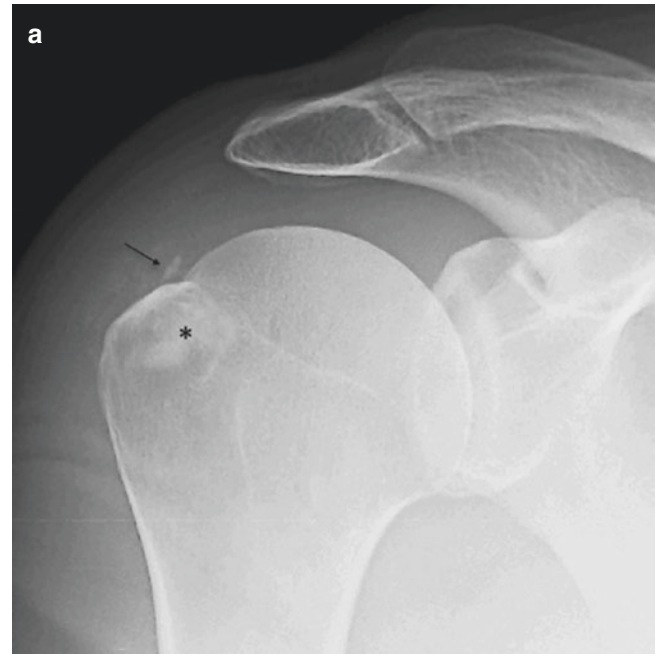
Intrabone migration of hydroxyapatite deposition, (a) AP radiographs demonstrate calcifications in the greater tuberosity surrounded by a radiolucency area (*). Calcifications within the rotator cuff space help for the diagnosis of hydroxyapatite deposition disease. (b) Coronal FSE PD fat sat WI shows the same features of calcifications within the greater tuberosity (*) surrounded by a hyperintense halo (arrow)
